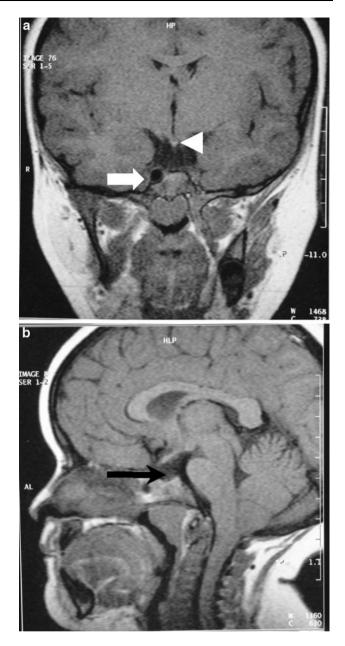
a a coronal T1-weighted image shows ectopic posterior lobe pituitary as a small hyperintense nodule in the median eminence (*arrowhead*). The left internal carotid artery (ICA) is absent while the right internal carotid artery is normal (*bold arrow*). b A sagittal T1-weighted image shows the absence of the anterior pituitary in the flat sella turcica as well as the absence of pituitary stalk (*arrow*)
